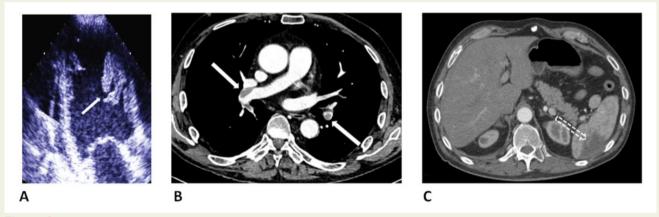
Transthoracic echocardiography in the same patient as in *Figure 2* following an embolic systemic episode while on heparin therapy. (A) The left apical ventricular thrombus is no more evident and the mid-septal thrombus (arrow) looks bilobulated but not vacuolated. Computed tomography short-axis views shows bilateral pulmonary (*B*, solid arrows) and splenic (*C*, dashed arrow) embolism.
